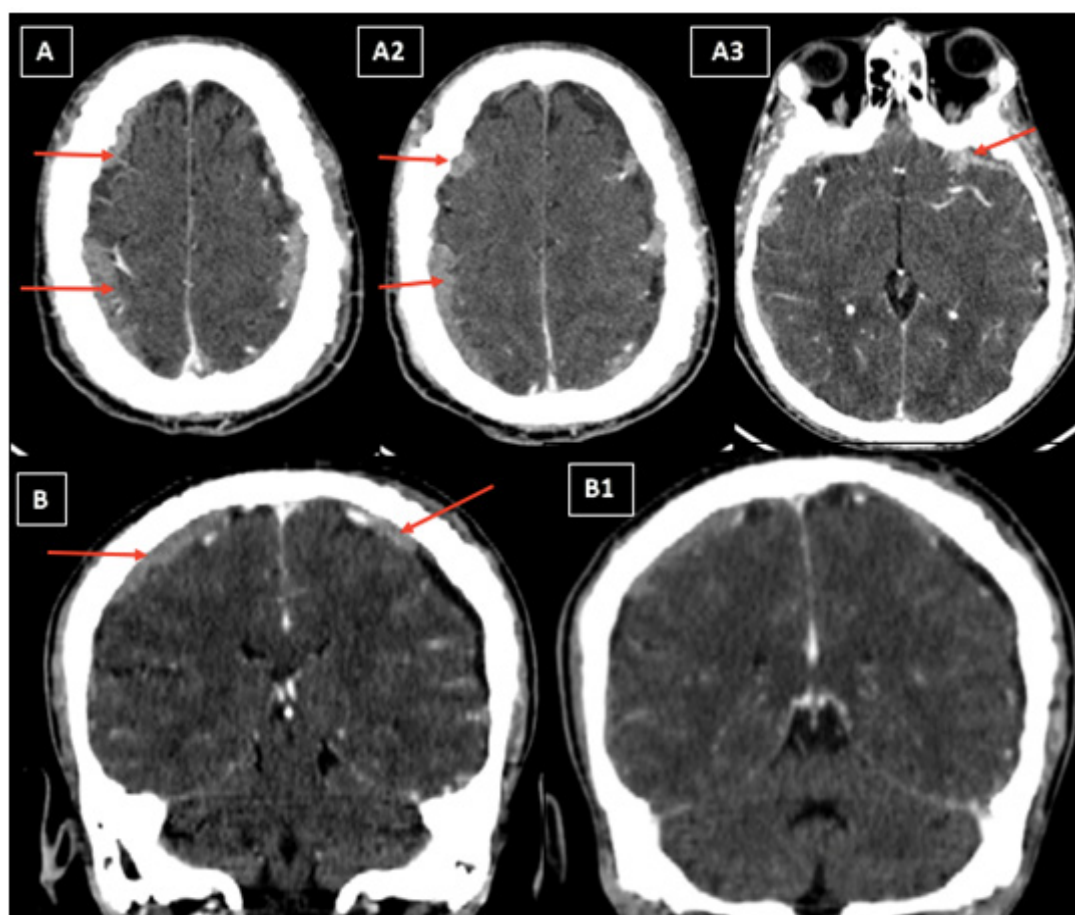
Axial contrast enhanced cerebral CT (A,A1,A2) with sagittal reconstructions (B,B1) : Thickness and enhancement of the dura of the convexity and the base respecting the dura of the falx cerebri and tentorium cerebelli (Red Arrows).
